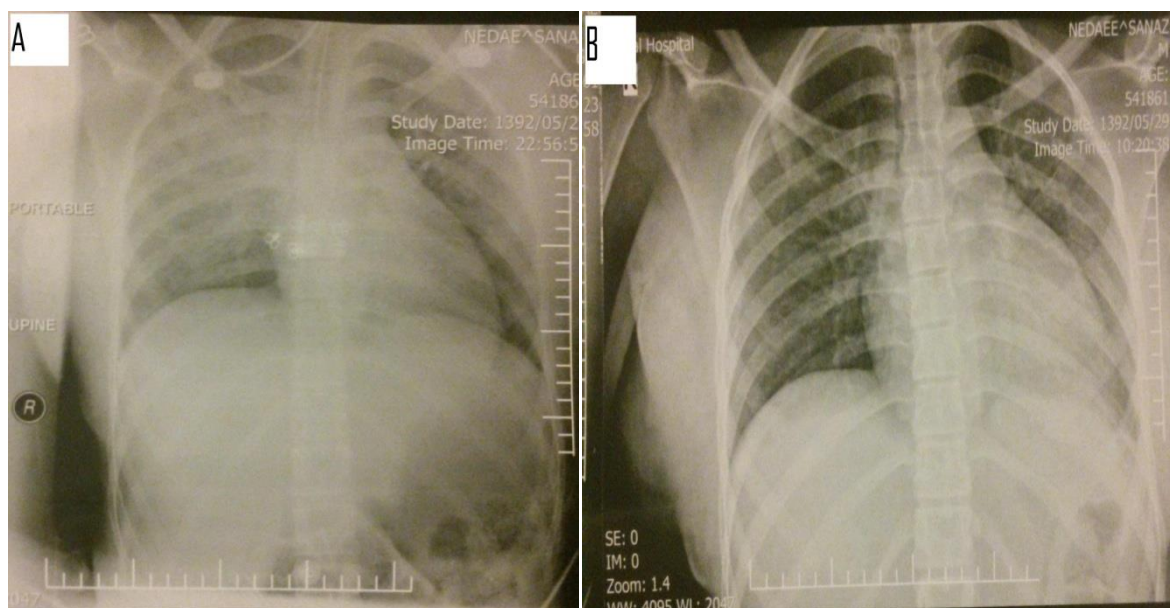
It shows diffuse lung opacities in patients after intubation (A) Air bronchogram view on chest x-ray (B).
